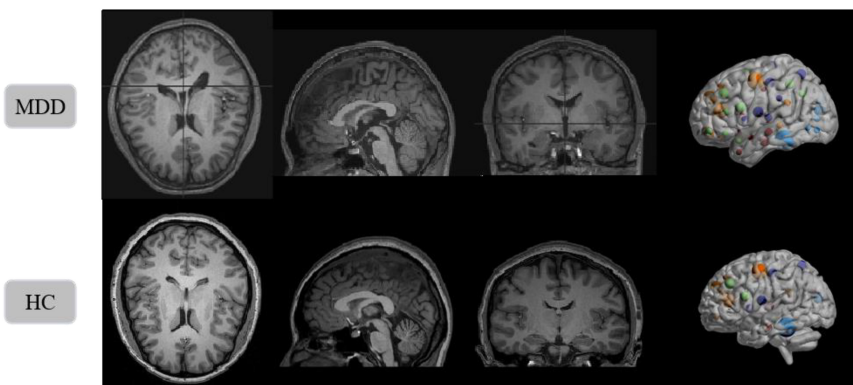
Structural magnetic resonance imaging slice images from the MDD and HC in SHH dataset. Left to right: axial view, sagittal view, coronal view, and 3D presentation.
